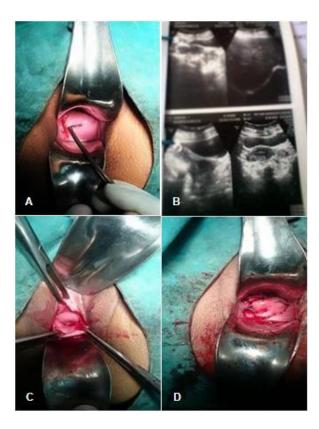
Case 2: A) Microperforation present around the midpoint of the transverse vaginal septum before the operation B) Transabdominal ultrasound reveals transverse vaginal septum in the upper part of the vagina with a hematocolpos. C) Resection of the TVS showing the cervical opening D) along with blood clot.
